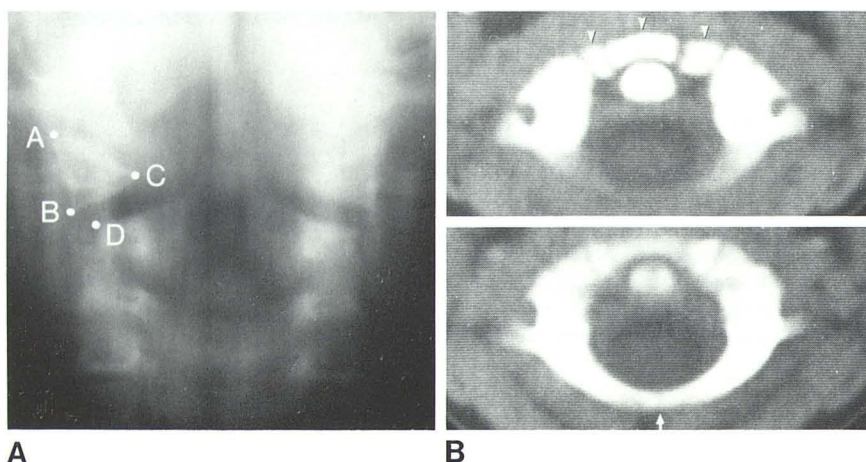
2½-year-old boy. A, AP tomogram shows pseudospread and points A, B, C, and D (see text). B, Contiguous CT slices show intact C1 ring. Posterior synchondrosis (arrow) is slitlike. Unusual tripartite ossification center in anterior arch (arrowheads) shows normal unequal spacing [3–5].
